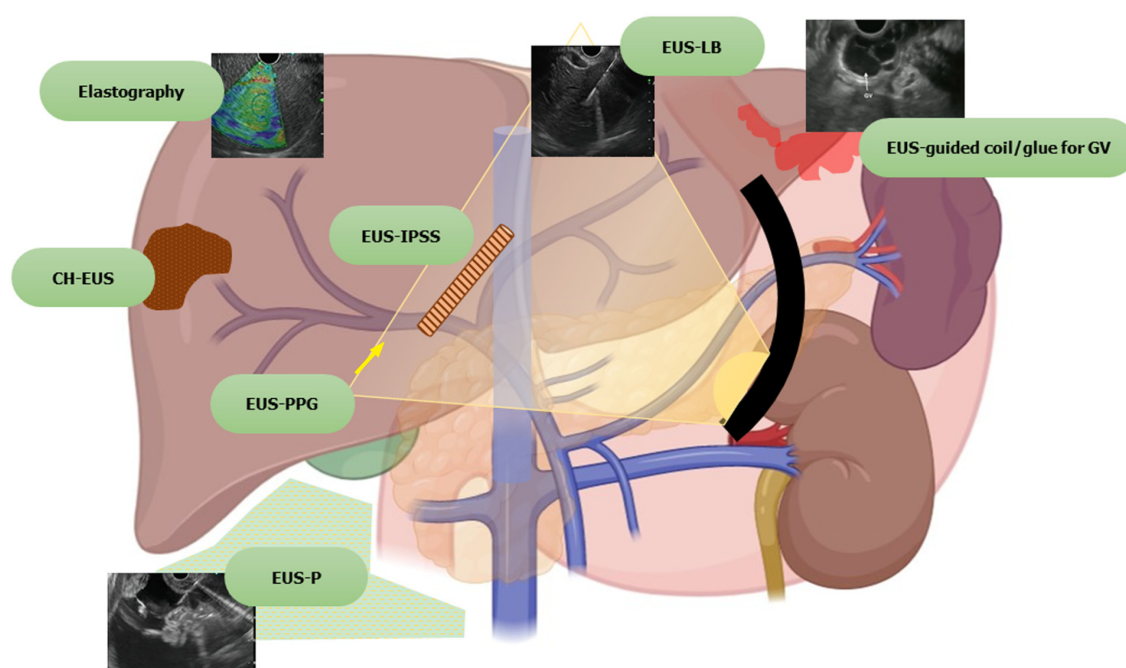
Spectrum of endoscopic ultrasound in hepatology. EUS: Endoscopic ultrasound; CH-EUS: Contrast harmonic endoscopic ultrasound; EUS-IPSS: Endoscopic ultrasound guided intrahepatic portosystemic shunt; EUS-LB: Endoscopic ultrasound guided liver biopsy; EUS-PPG: Endoscopic ultrasound guided portal pressure gradient; EUS-P: Endoscopic ultrasound guided paracentesis; GV: Gastric varices.
